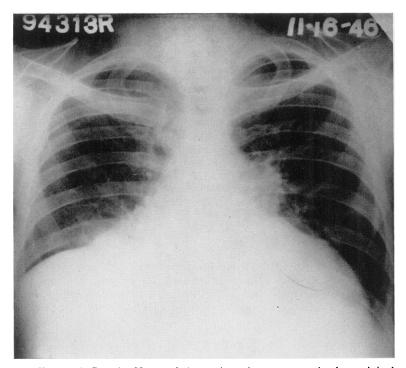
Case 1. X-ray of chest taken about one month after original hospital admission. The right pleural effusion has nearly disappeared. Gross increase in the cardiac size is obvious, as are the evidences of pulmonary congestion.
